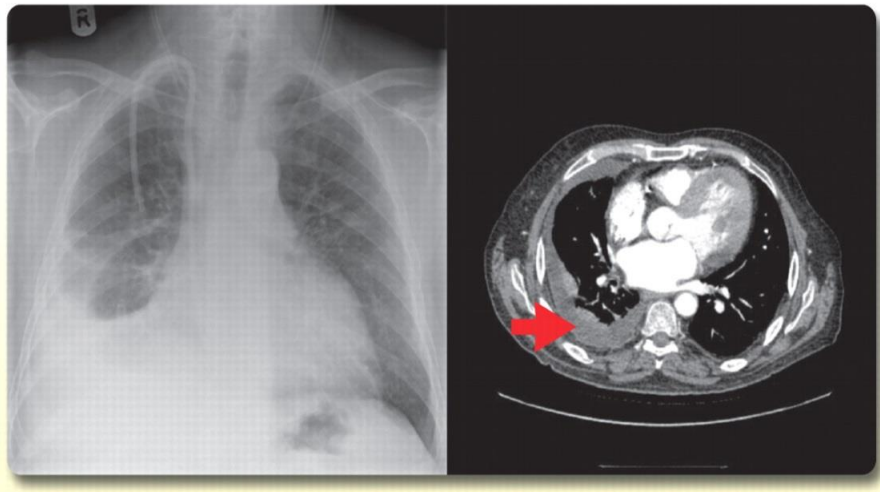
pleural effusion chest x-ray and CT-scan (*McGrath and Anderson., 2011*).
